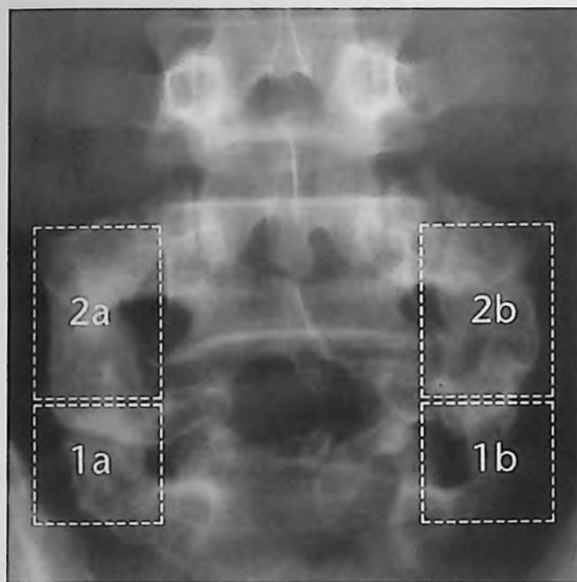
An antero-posterior radiograph showing the evaluation procedure used in assessment of the posterolateral spinal fusion. Each level and each side were judged separately. Continuous intertransverse bony bridge on a minimum of one of the two sides (a. or b.) indicated a fusion at that level. "Fusion" indicated this quality of fusion at all intended levels.
